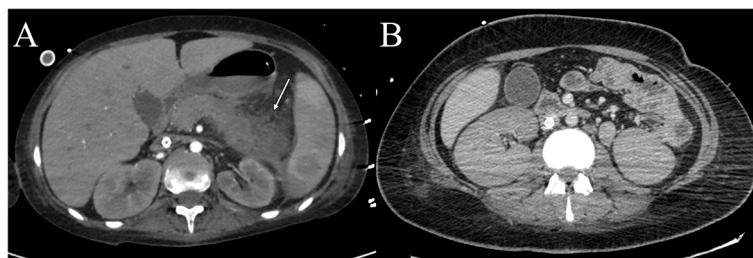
Axial abdominal contrast-enhanced CT image of a severely ill patient infected with SARS-CoV-2 virus and admitted to ICU undergoing ECMO treatment with a sudden worsening of symptoms revealing a diffusely enlarged and edematous pancreatic tail, with ill-defined borders, stranding of the peri-pancreatic fat and presence of free peri-pancreatic fluid, highly suggestive of acute pancreatitis (arrow in A). Axial contrast-enhanced CT image of an ICU patient with COVID-19 ARDS in ECMO treatment revealing an enlargement of both kidneys and the loss of corticomedullary differentiation, compatible with an acute kidney injury (B)
